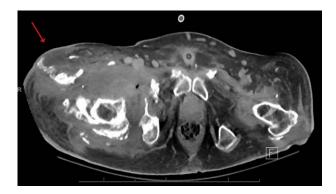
Preoperative computed tomography scan demonstrating extensive right-sided osteomyelitis (red arrow).
